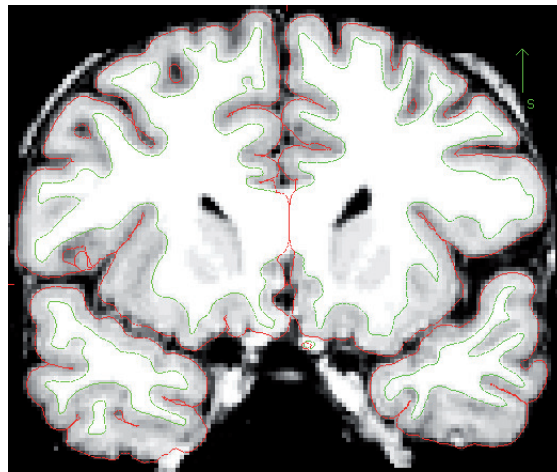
Volumetric T1-weighted brain image with automatically generated surface models. Green: white surface; red: pial surface.
